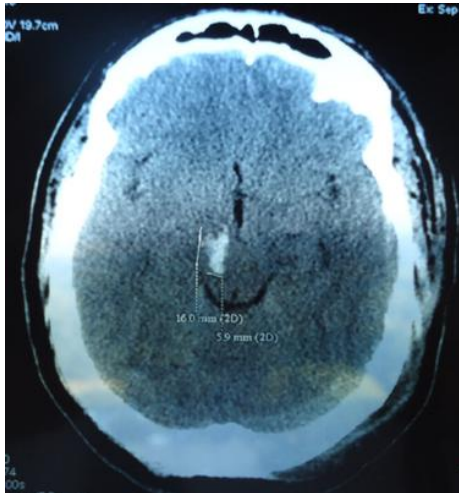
CT of brainstem (midbrain) contusion
